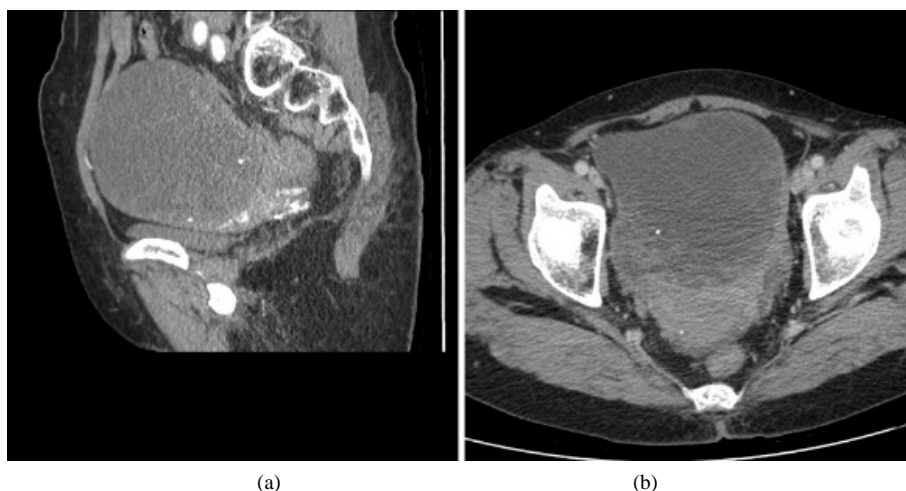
Enhanced pelvic CT: sagittal (a), coronal (b) pelvic cavity showed mass-like mixed density shadows, the largest cross-section is about 122.5 mm × 140.1 mm, mainly cystic components, and nodular calcification shadows can be seen
